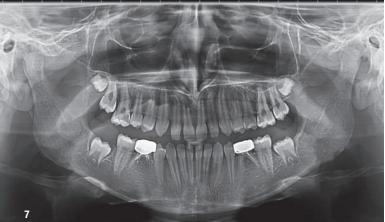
Five-year follow-up panoramic radiograph.
